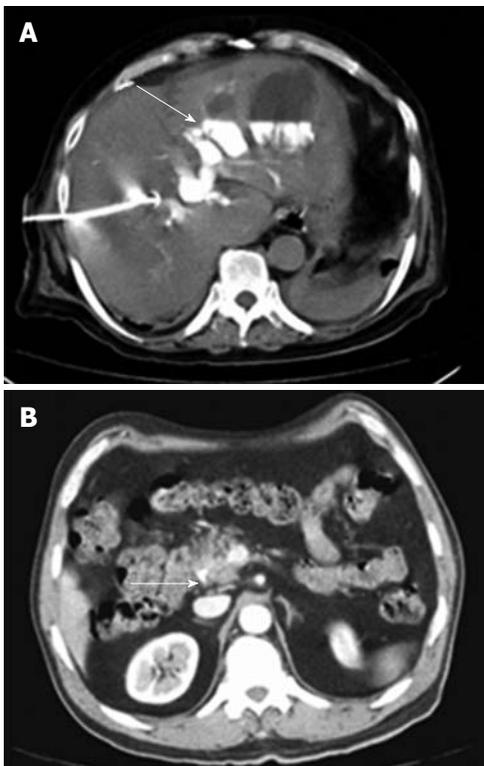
A case of obstructive jaundice secondary to head of pancreas cancer obstructing the common bile duct. A: Computed tomography (CT)-guided percutaneous transhepatic cholangiography shows opacification of markedly dilated intrahepatic biliary radicles (arrow); B: CT-guided internal drainage stent seen along the course of the common bile duct surrounded by the pancreatic mass (arrow).
